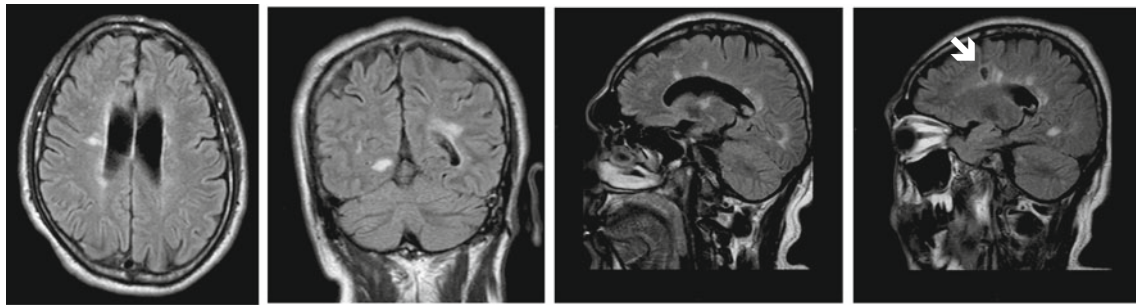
Characteristic MS periventricular white matter lesions along with a black hole (*arrow*). Last to appear on the MRI are the so called “black holes”, which are irreversible, equivalent to axonal destruction and loss of brain substance
